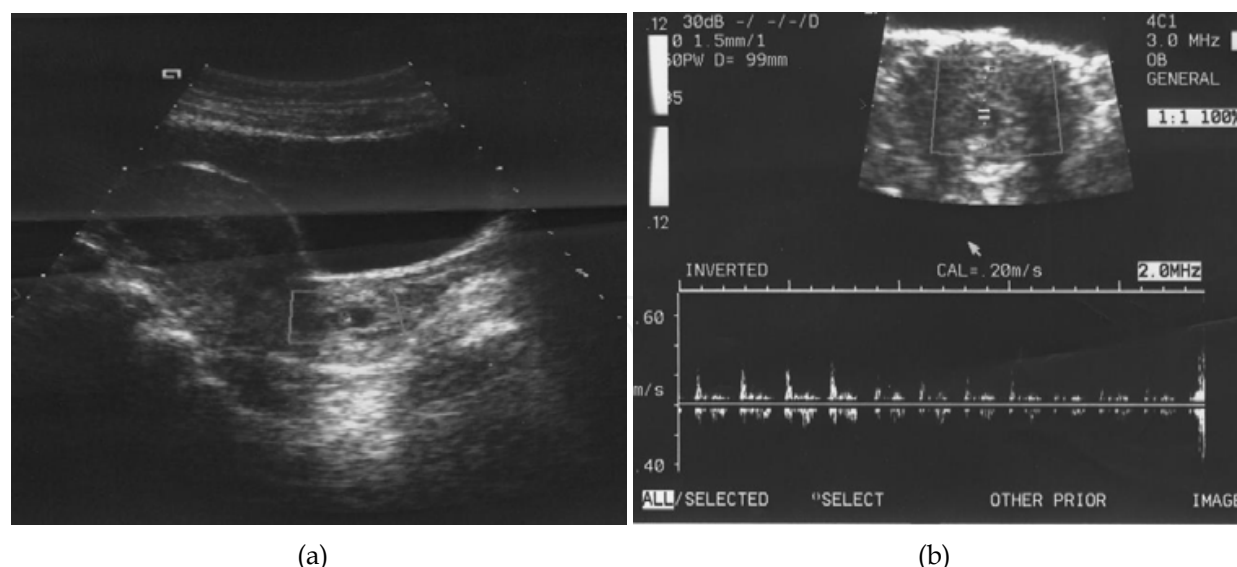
(a) Ultrasonographic scan of a case of cervical pregnancy. The gestational sac is evident under the closed internal os. (b) Doppler flow velocimetry depicting fetal cardiac activity. (Xu, et al. J Obstet Gynaecol Res. 2007;33:190-4)
